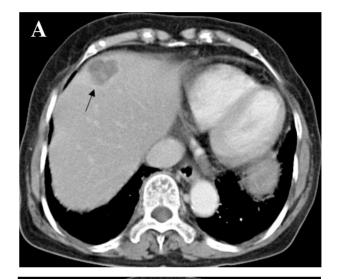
Enhanced computed tomography scans of case 1 showing an intrahepatic metastatic tumor (Fig. 2A) exhibits peripheral ring enhancement in the right hepatic lobe (arrow), whereas the main tumor with central necrosis (C) without contrast enhancement in the left hepatic lobe (Fig. 2B).
